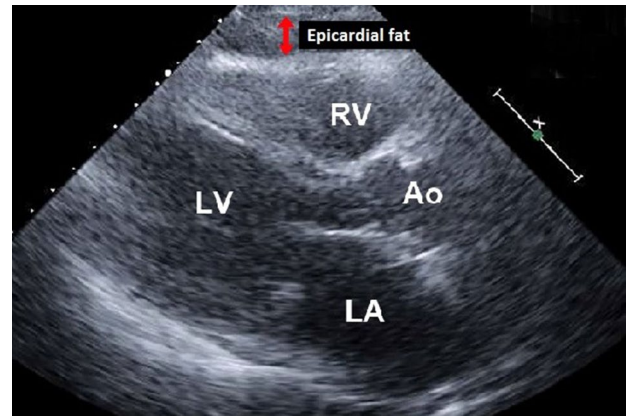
Echocardiography in the parasternal long-axis view of a 36-year-old male with HS showed an EFT of 7.1 mm. Ao aorta; LA left atrium; LV left ventricle; RV right ventricle
